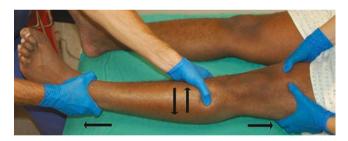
(a) Lateral knee dislocation on AP radiograph (photo courtesy L. Ganti, MD). (b) Lateral dislocation of the knee: the proximal tibia is pushed in a medial direction
